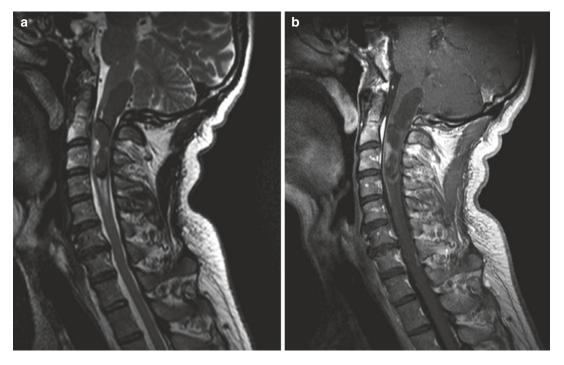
Initial MRI scan: Preoperative MRI showing a contrast enhanced spinal cord tumor between the medulla oblongata and the C3 level with an associated syrinx formation (Sagittal T2 in \mathbf{a} , sagittal contrast T1 in \mathbf{b})
